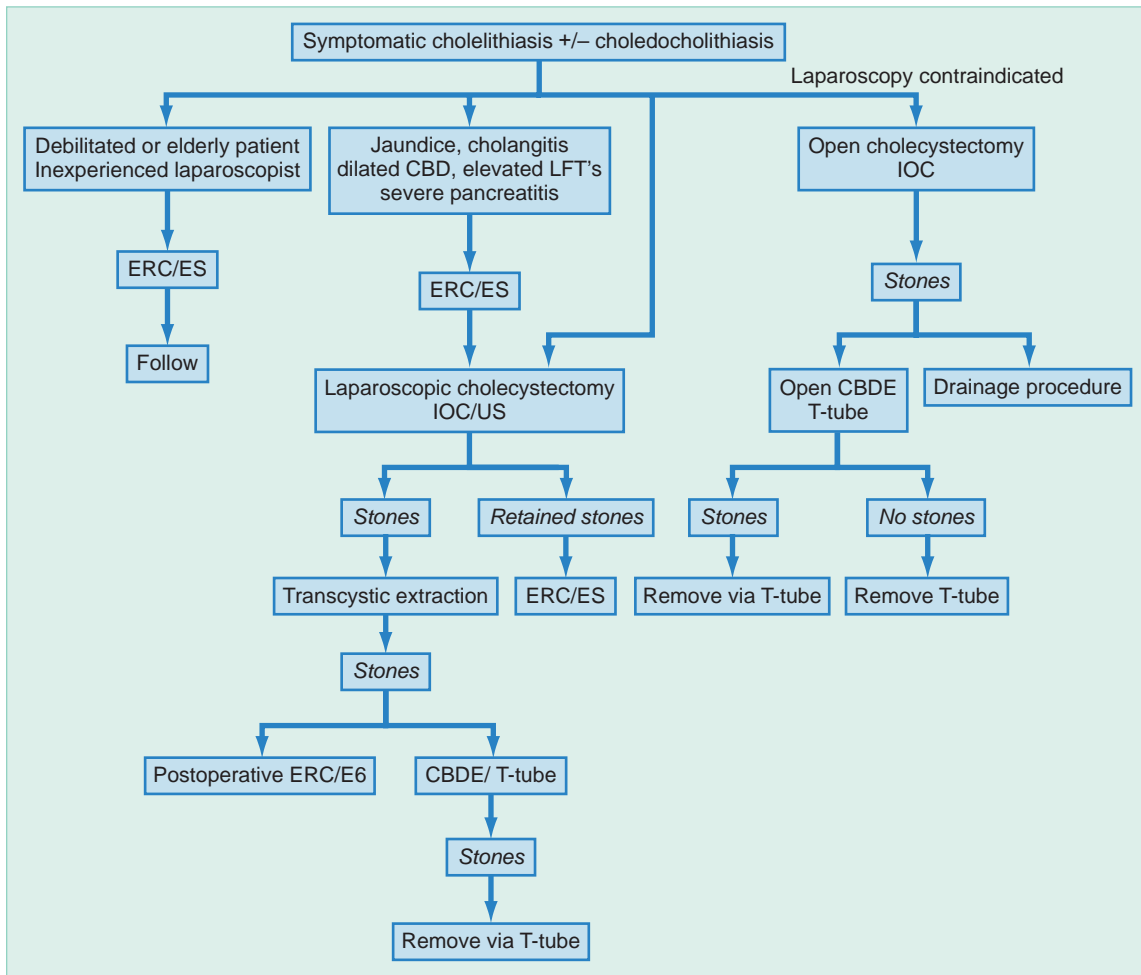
Management algorithm for treatment of common bile duct (CBD) stones. This approach assumes that the laparoscopist is experienced in transcystic techniques and that ERC/ES is at least 90% successful at CBD stone clearance. CBDE, common bile duct exploration; ERC, endoscopic retrograde cholangiography; ES, endoscopic sphincterotomy; LFT, liver function test; IOC, intraoperative cholangiography; US, laparoscopic ultrasonography. (From Jones DB, Soper NJ: The current management of common bile duct stones. *Adv Surg* 29:271, 1996.)
